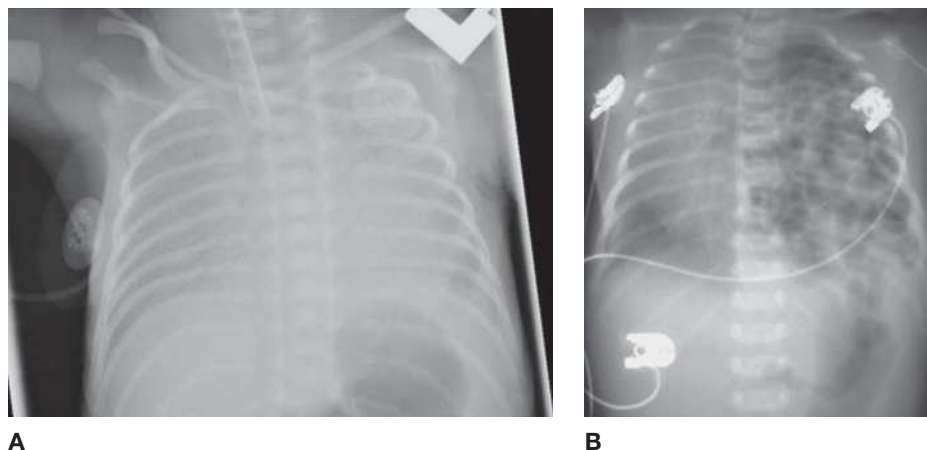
Neonatal respiratory distress. (A) Frontal CXR in a neonate with respiratory distress syndrome showing diffuse fine granular (“ground-glass”) opacities and hypoaeration. (B) Frontal radiograph in a patient with congenital diaphragmatic hernia, demonstrating air-filled loops of bowel in the left chest and rightward displacement of mediastinal structures. (Image A reproduced with permission from USMLE-Rx.com. Image B reproduced with permission from Brunicaudi FC et al. *Schwartz’s Principles of Surgery*, 9th ed. New York: McGraw-Hill, 2010, Fig. 39-3.)
